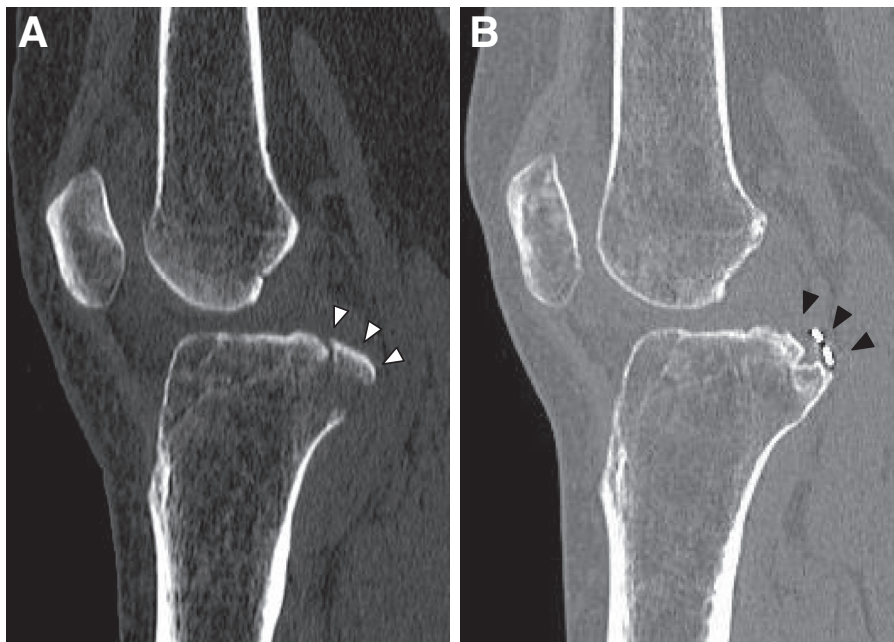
(A) Preoperative sagittally reconstructed computed tomography image of left knee, identifying a type III avulsion fracture (white arrowheads). (B) Bone union was confirmed after 3 months, and remodeling of the fragment (black arrowheads) was seen by 12 months after surgery.
